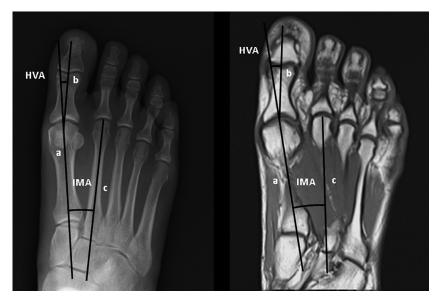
Measurement of hallux valgus angle (HVA) and intermetatarsal angle (IMA) on a radiograph and magnetic resonance image. *Line a* passes through the midpoint of the first metatarsal head and base, *line b* passes through the midpoint of the head and base of the first proximal phalanx, and *line c* passes through the midpoint of the second metatarsal head and base. The HVA measures the acute angle between *lines a and b*, and the IMA measures the acute angle between *lines a and c*.
